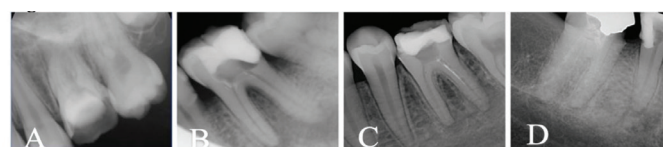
A: Intraoral periapical radiograph (IOPA) of an upper first molar that root canal treatment was previously initiated with a defective restoration, insufficient coronal seal leads to re-infection of root canal system and therefore causes interappointment flare up. B: IOPA showing lower first molar that is previously accessed the periapical radiolucency the flare up in this case is due to contamination from the periapical region. C-D: IOPA of a lower first molars with defective coronal seal and periapical lesion.
